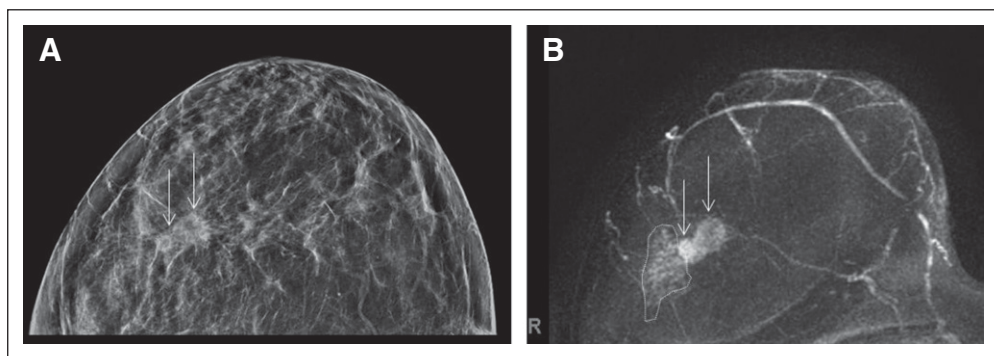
A 62-year-old patient underwent screening mammography and Digital Breast Tomosynthesis (DBT). The breast is nondense (ACR density category A, almost entirely fatty breast). The screening DBT (A) reveals two spiculated masses in the upper outer quadrant (arrows). Ultrasound (not shown) confirms presence of two masses, 8 mm and 14 mm in diameter. Ultrasound-guided core biopsy reveals invasive breast cancer, no special type, luminal B subtype, in both masses. Magnetic resonance imaging (MRI) (B) depicts the two invasive cancers, plus a large segment of non-mass enhancement suggestive of an intraductal component (dotted line) that was occult both on DBT and ultrasound. Surgery after MR-guided bracketing confirmed presence of an extensive DCIS component in addition to the invasive cancer.
